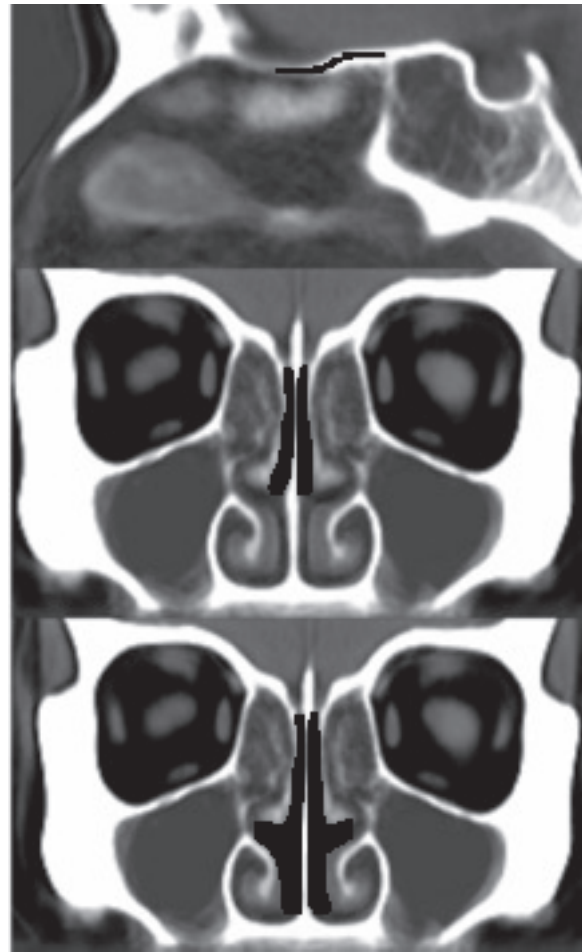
Volumes of interest (VOI) in the template space for automated CT measurements of (A) the cribriform plate, (B) olfactory cleft volume, and (C) total intranasal volume.
